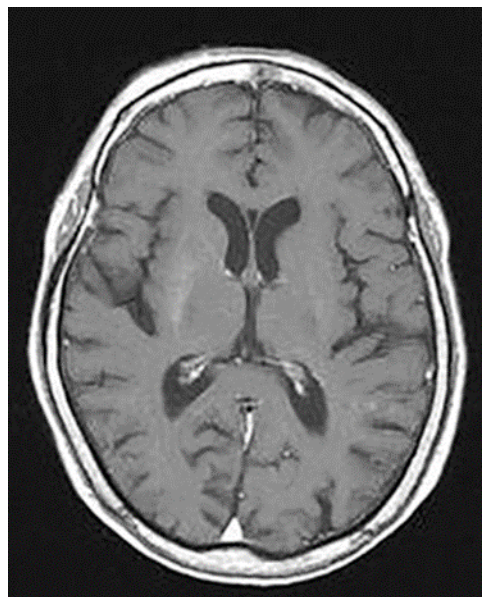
T1 weighted MRI Brain showing hyperintensity in right basal ganglia
